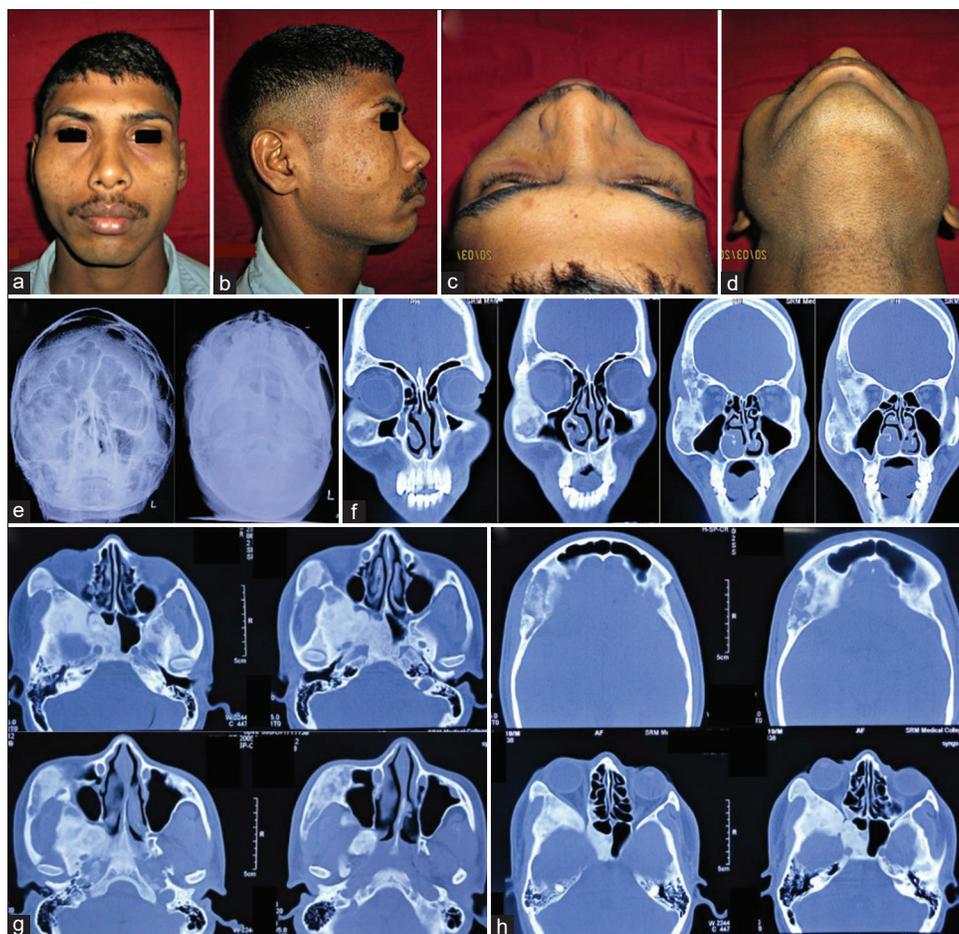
(Case 3) (a-d) Facial asymmetry caused by a bony enlargement of the mid-third of the face on the right. (e) Radiographs showing a diffuse opacified expansion of Rt Zygomatic complex. (f) Noncontrast computed tomography demonstrating diffuse expansion of the zygomatic complex and temporal bone, which had a granular, “ground-glass” appearance with indistinct margins which blended with the adjacent normal-appearing bone. (g and h) Opacification of the base of the skull in the region of the middle cranial fossa, contiguous involvement of the basisphenoid, greater and lesser wings of sphenoid including the sella turcica
